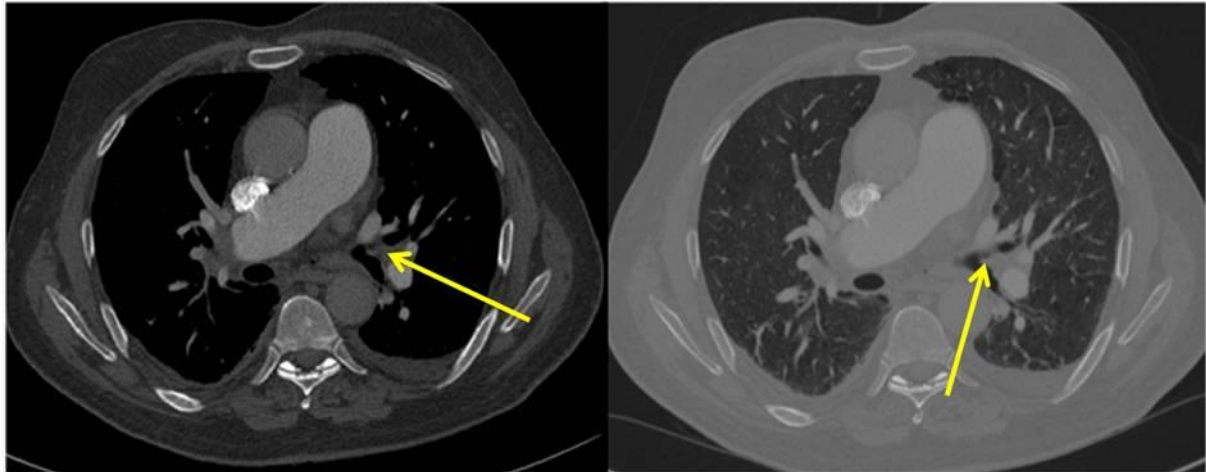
Computed tomography of chest: irregular obstruction of the proximal portion of the left upper lobe bronchus by a soft-tissue endobronchial mass (yellow arrows).
